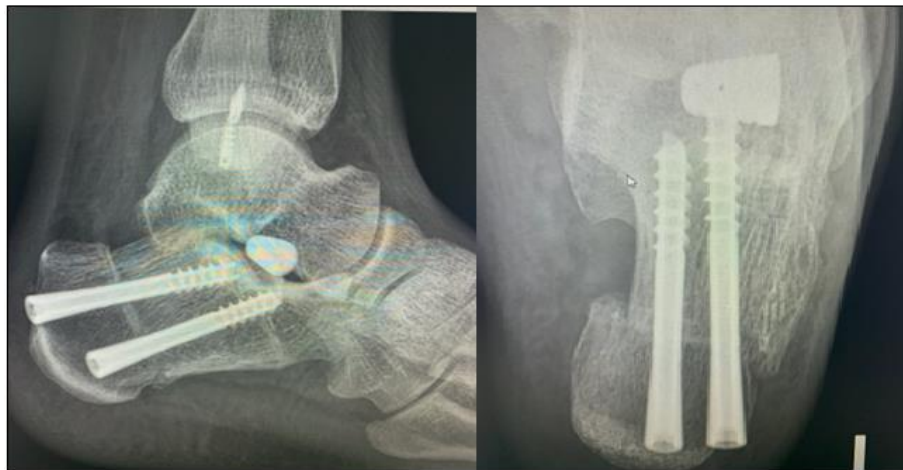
Horizontal lateral and posterior radiograph post screw and arthroereisis plug insertion.
